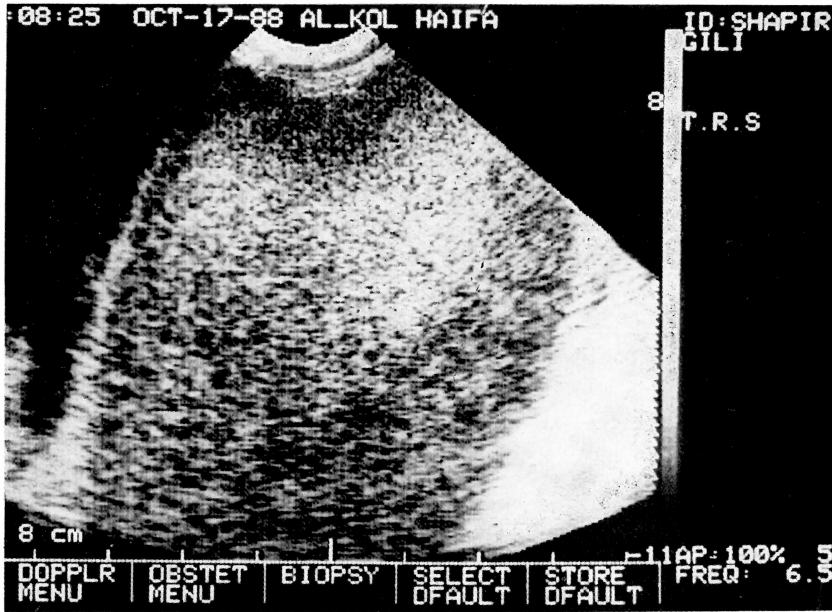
Transrectal sonography showing the mass between the rectum and bladder.
